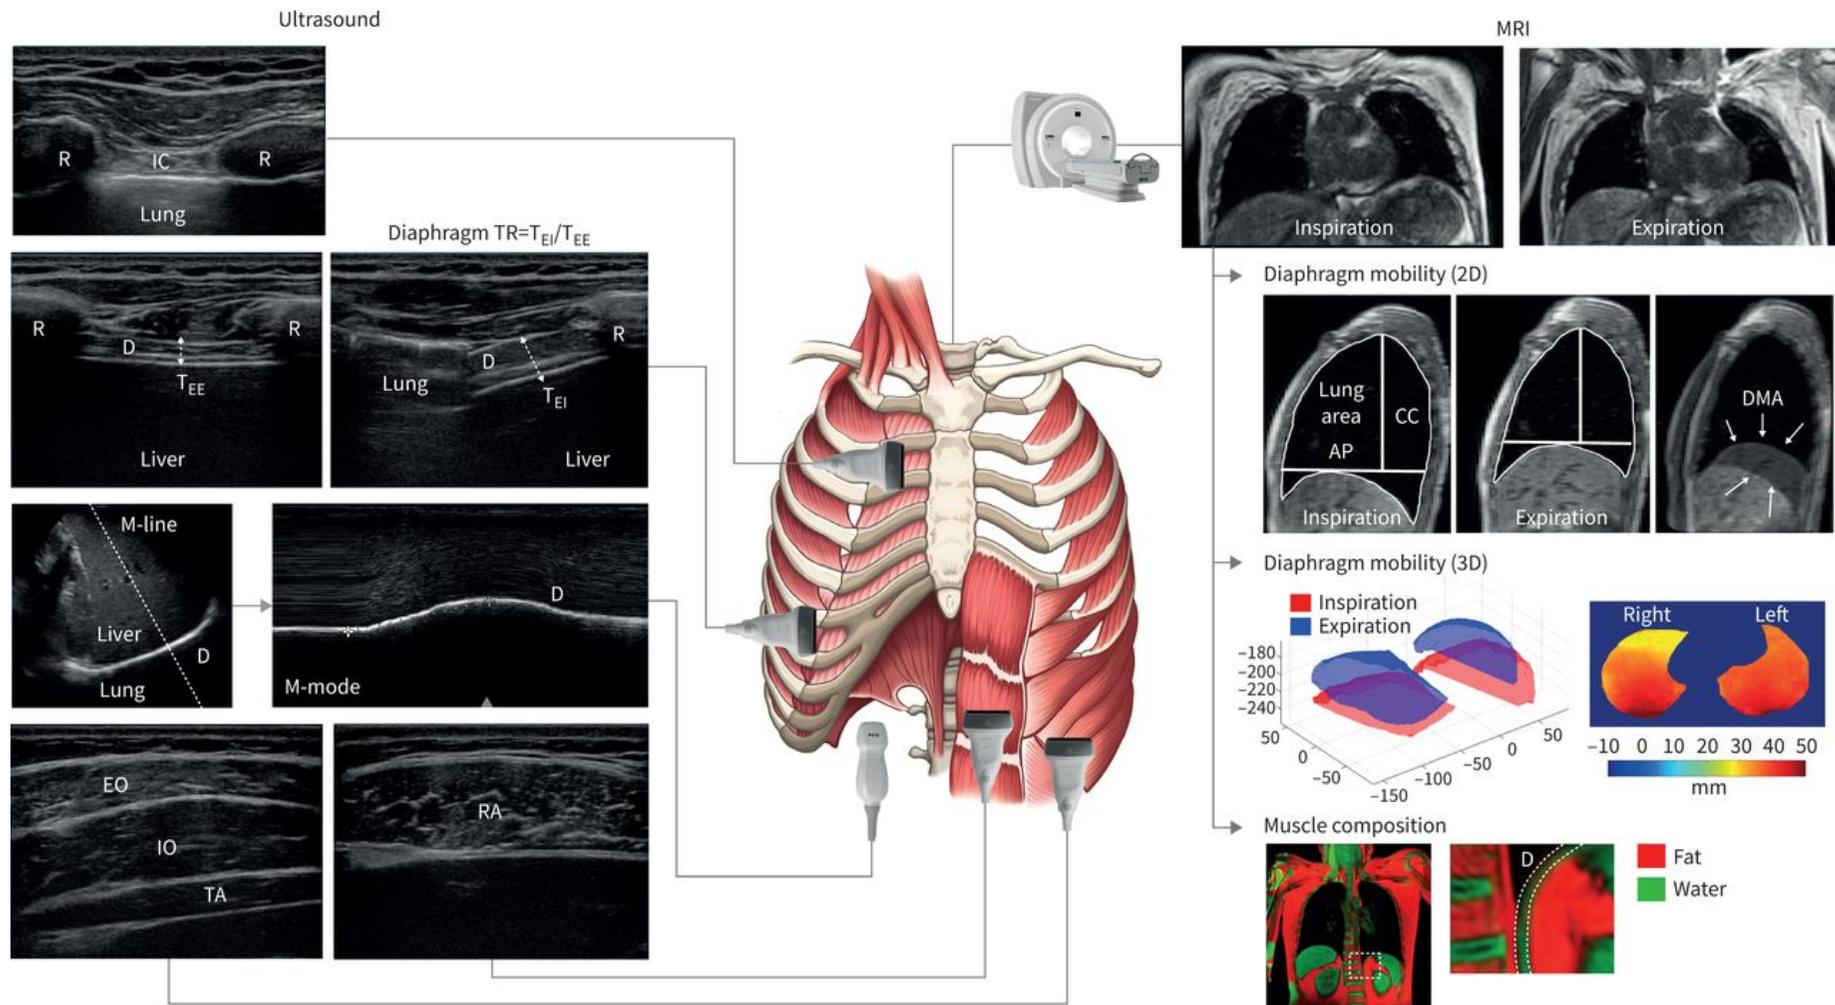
Overview of currently used respiratory muscle imaging techniques: ultrasound and magnetic resonance imaging (MRI). R: rib; IC: intercostal muscles; TR: thickening ratio; TEI: end-inspiratory thickness; TEE: end-expiratory thickness; D: diaphragm; EO: external oblique muscle; IO: internal oblique muscle; TA: transverse abdominal muscle; RA: rectus abdominis muscle; CC: cranio-caudal; AP: antero-posterior; DMA: diaphragmatic movement area [138].
